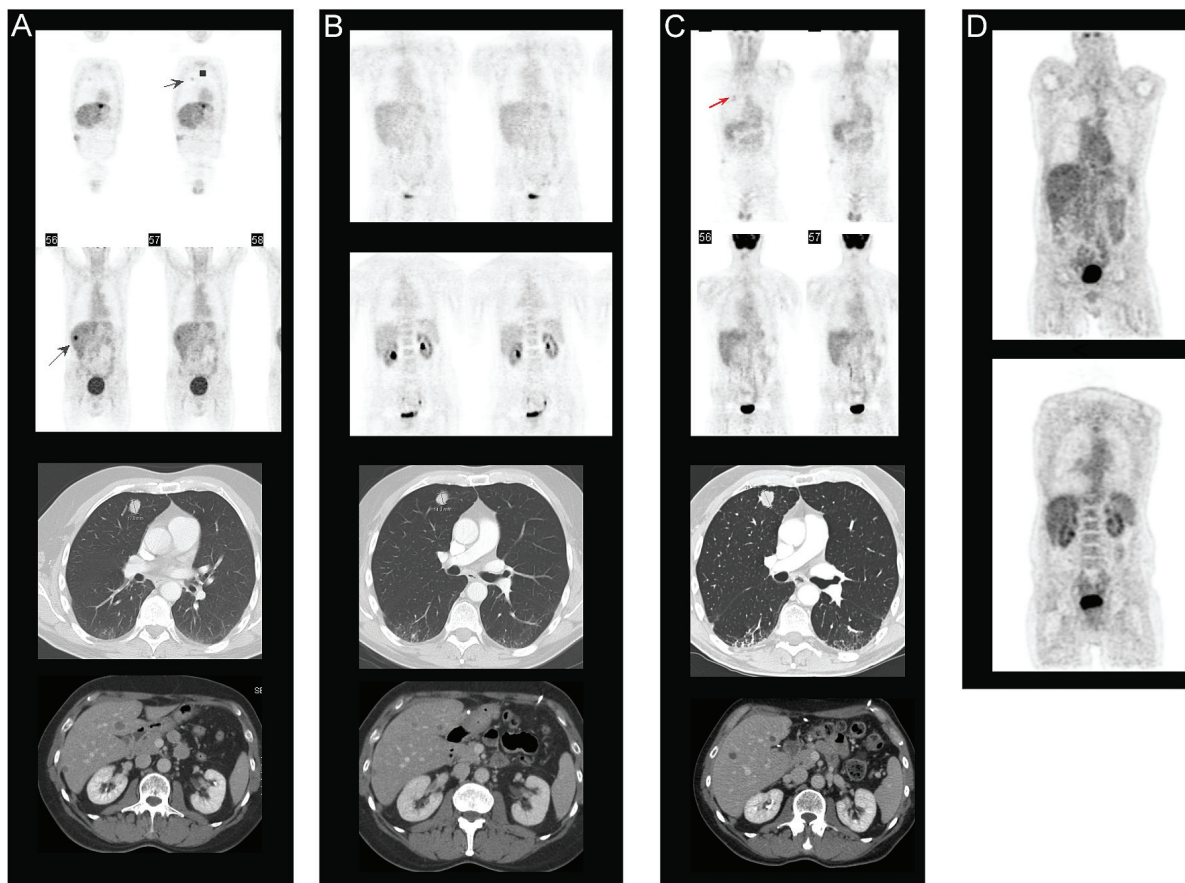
Chronology of disease evolution in the patient. (A) Assessment before start of intrahepatic arterial infusion (HAI): anterior radio-labelled fluorodeoxyglucose (FDG) positron-emission tomography (PET) images show FDG-positive bilobar liver metastases and a solitary lung metastasis (arrows). The corresponding computed tomography (CT) images of lung and liver are shown immediately below. (B) Assessment at the end of HAI, after a normalization of serum carcinoembryonic antigen: FDG-PET shows complete metabolic response. Corresponding CT images are shown immediately below. (C) Imaging by FDG-PET after reactivation of lung lesion and before conformal radiotherapy to treat progressive disease. Corresponding CT images of the liver show only leftover cystic lesions. (D) Most recent FDG-PET images reveal no FDG-positive lesions.
